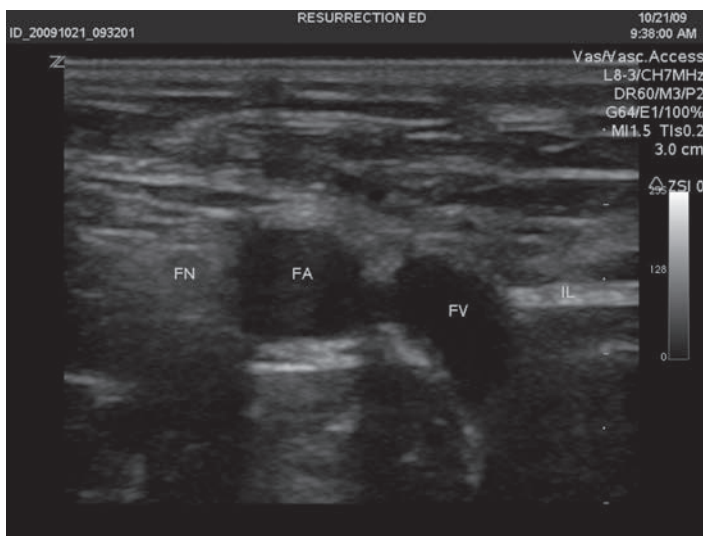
Ultrasound image of femoral vein (FV), artery (FA), nerve (FN) and inguinal ligament (IL).
